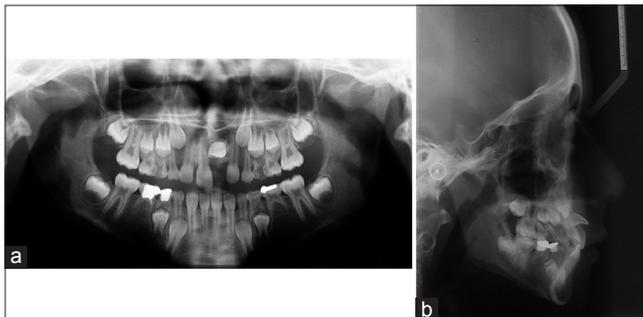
Pretreatment radiographs: (a) Panoramic radiograph; (b) lateral cephalometric radiograph.
